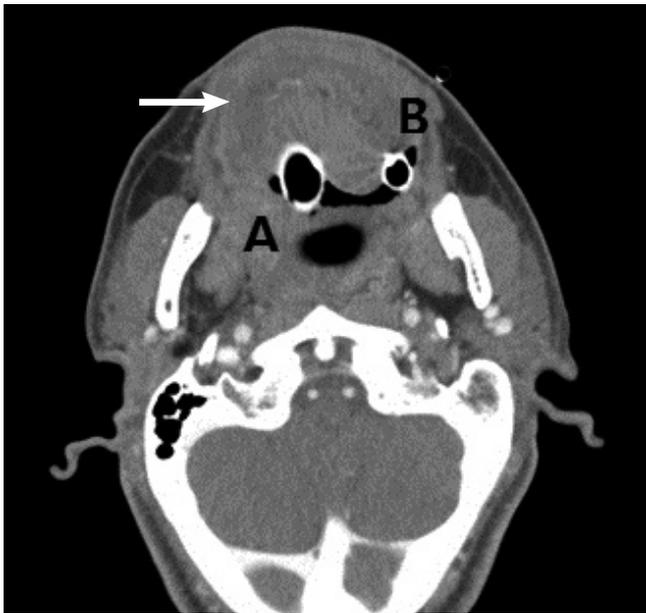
Computed tomography imaging after King laryngeal tube (A) and endotracheal tube (B) insertion. The laceration is shown (arrow).
